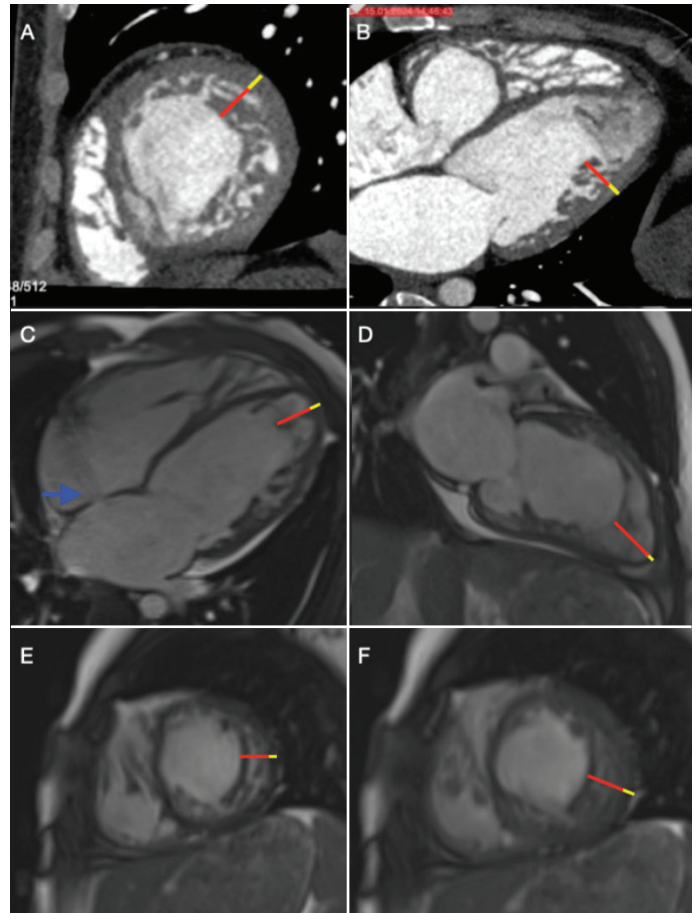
Detection of left ventricular hypertrabeculation by cardiac CT performed for coronary artery evaluation in a newly diagnosed dilated cardiomyopathy patient and confirmation of the diagnosis of hypertrabeculation with CMR. (A) Cardiac CT short-axis image. (B) Cardiac CT long-axis 4-chamber view. (C) CMR NC/C > 2.3 (Petersen criterion) at end-diastole on the long-axis (4-chamber) view. The blue arrow indicates a left-to-right shunt over a small atrial septal defect. (D) CMR NC/C > 2.3 (Petersen criterion) at end-diastole on the long-axis (2-chamber) view. (E) CMR NC/C ≥ 2 (Grothoff criterion parameter) on the short-axis view at end-diastole. (F) CMR NC/C ≥ 2 (Stacey criterion) on the short-axis view at end-systole. The yellow line represents the compacted layer, and the red line represents the noncompacted layer.
